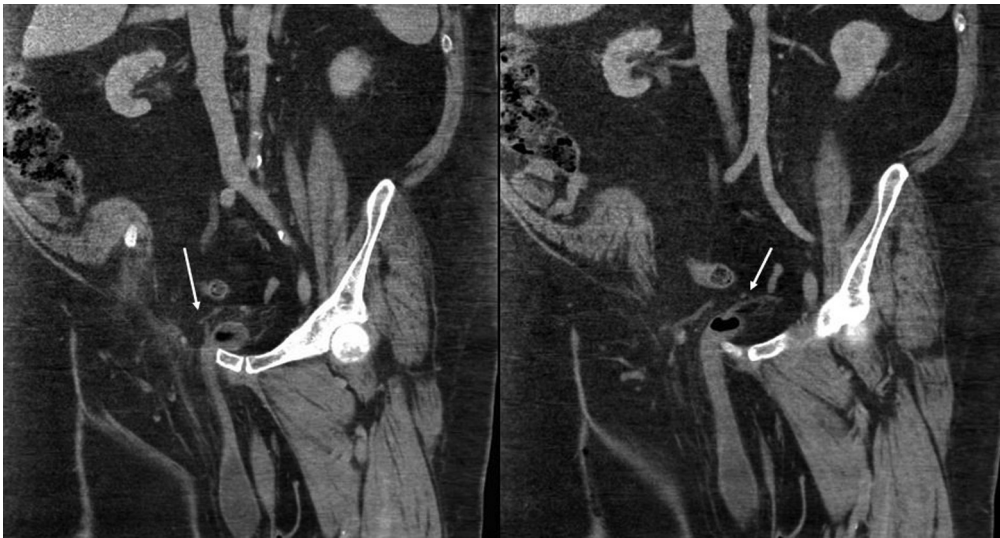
CT Scan from 1 year prior to presentation. Left and right ureters noted inserting into the bladder inside the bony pelvis (arrows).
